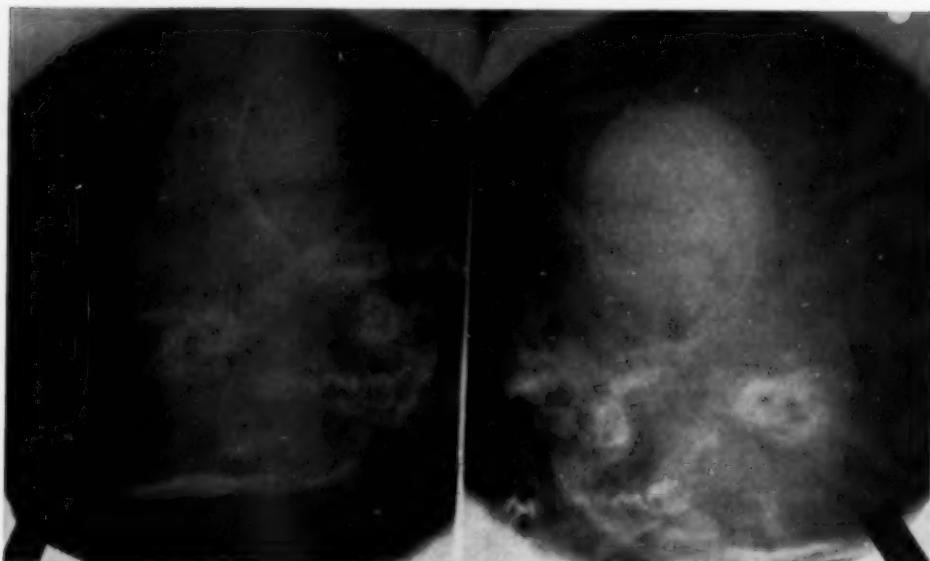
(Ladenheim and Metrick). X-ray view of orbit, showing patency of optic foramen bilaterally.
